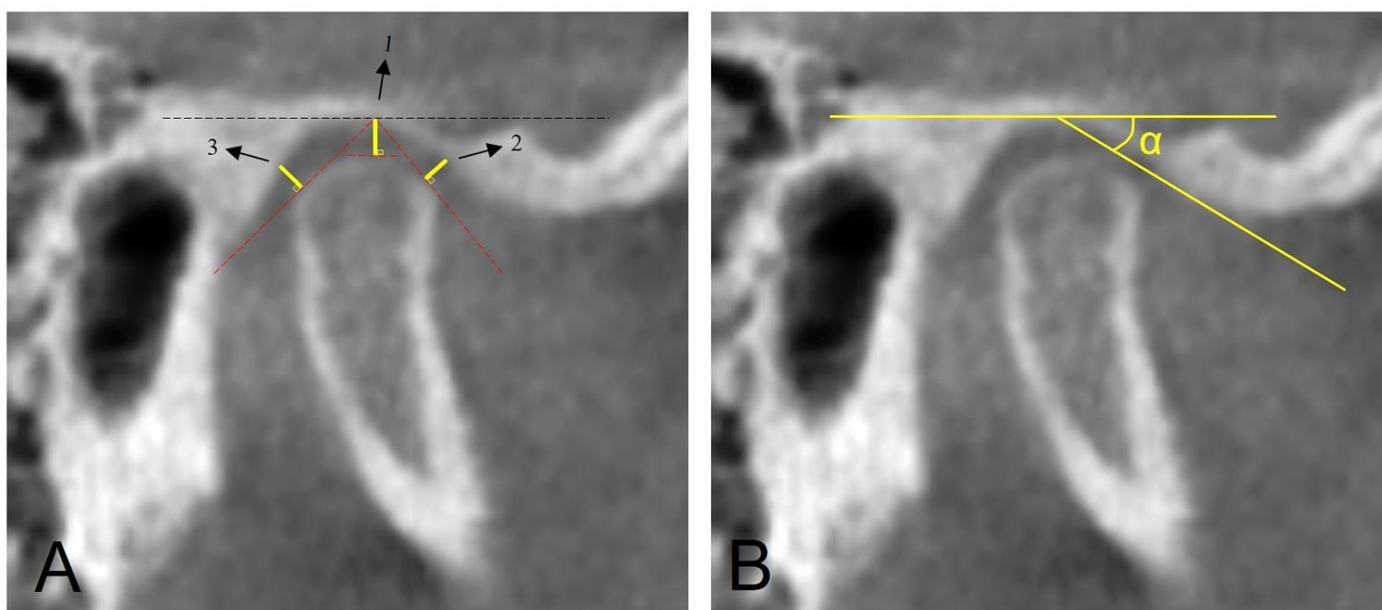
A) Cone-beam computed tomography images of measurement of superior, anterior, and posterior joint spaces 1: Superior joint space, 2: Anterior joint space, 3: Posterior joint space. B) Cone-beam computed tomography image of the articular eminence inclination
